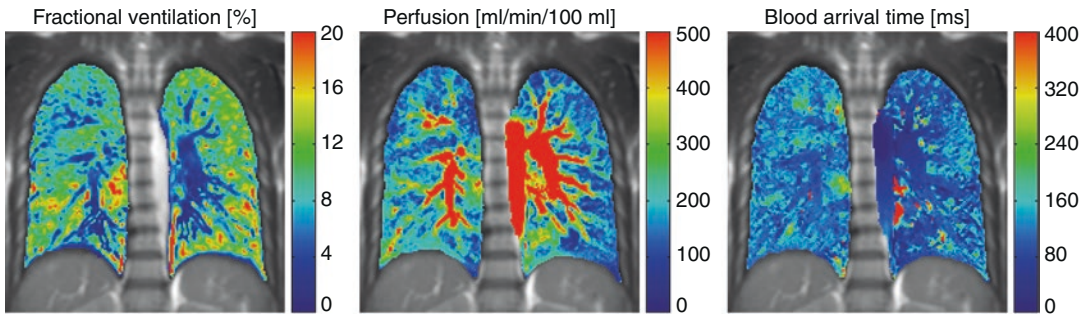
Fractional ventilation, perfusion, and blood arrival time maps obtained using FD MRI in a healthy volunteer
